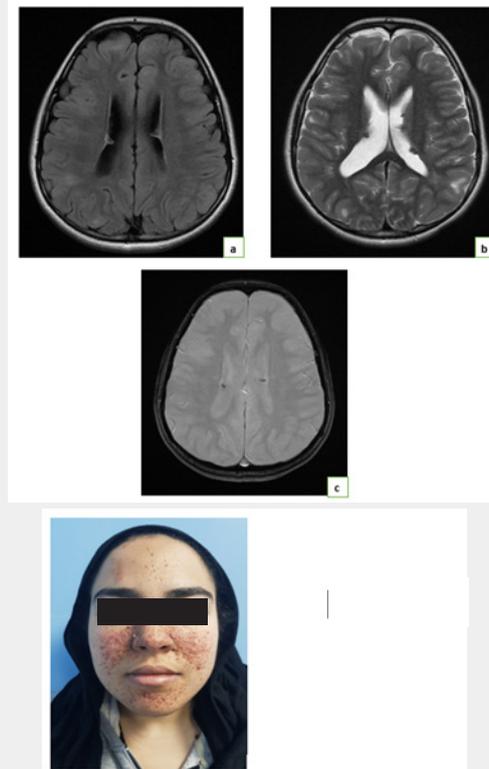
MRI of the Axial Cut FLAIR before (a), axial T2 (b) and axial T2 (c) showing signal abnormalities of SB on the tentorial floor in relation to OBN. cortical tubers and nodules under partially calcified ependymal. 26-year-old patient followed by epileptic seizures and e de 26.
